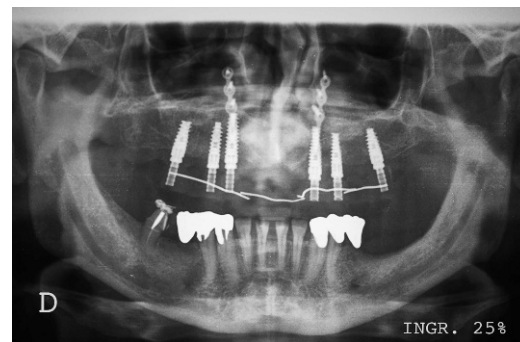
Postimplant orthopantomography.
